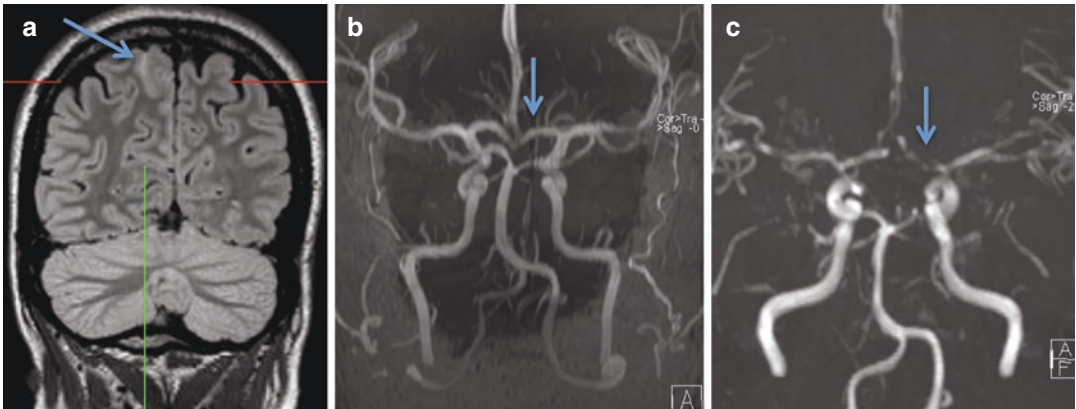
Reversible cerebral vasoconstriction syndrome (RCVS) in a 35-year-old woman who presented with repetitive right occipital headache attacks since 4 days. Coronal FLAIR MRI (a) shows right parietal sulcal subarachnoid effusion (a: arrow). Initial TOF-MRA (b)
